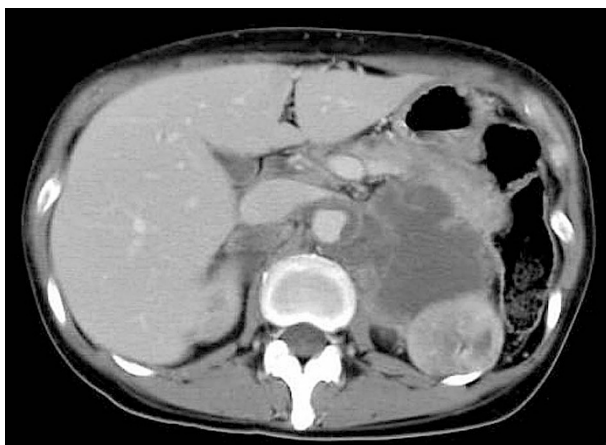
Follow-up CT scan image showing a huge retroperitoneal tumor mass encasing the aorta and invading the tail of the pancreas.
